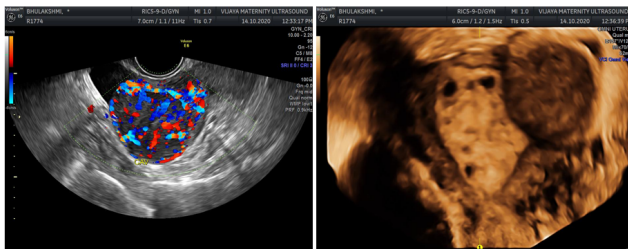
Ultrasound image showing a Fibroid with increased vascularity and 3D Ultrasound showing the Fibroid on the right cornual end
